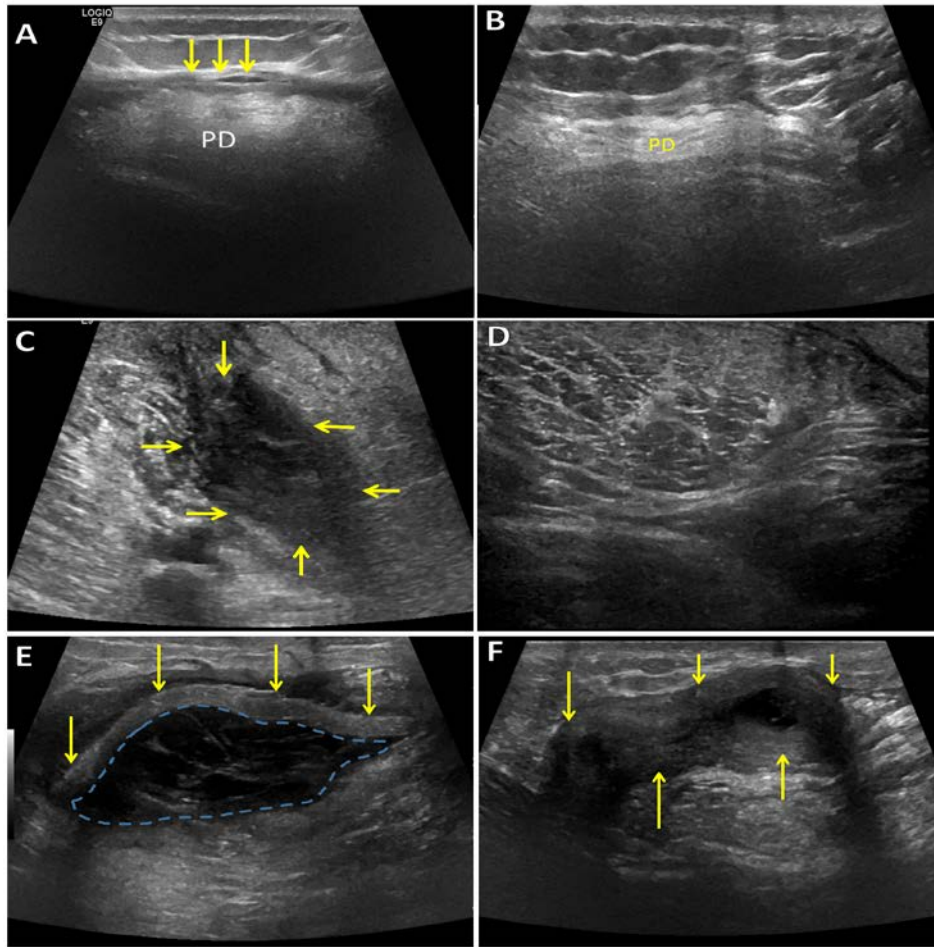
Ultrasound imaging shows that ECM bioscaffolds degrade upon implantation. (A)
